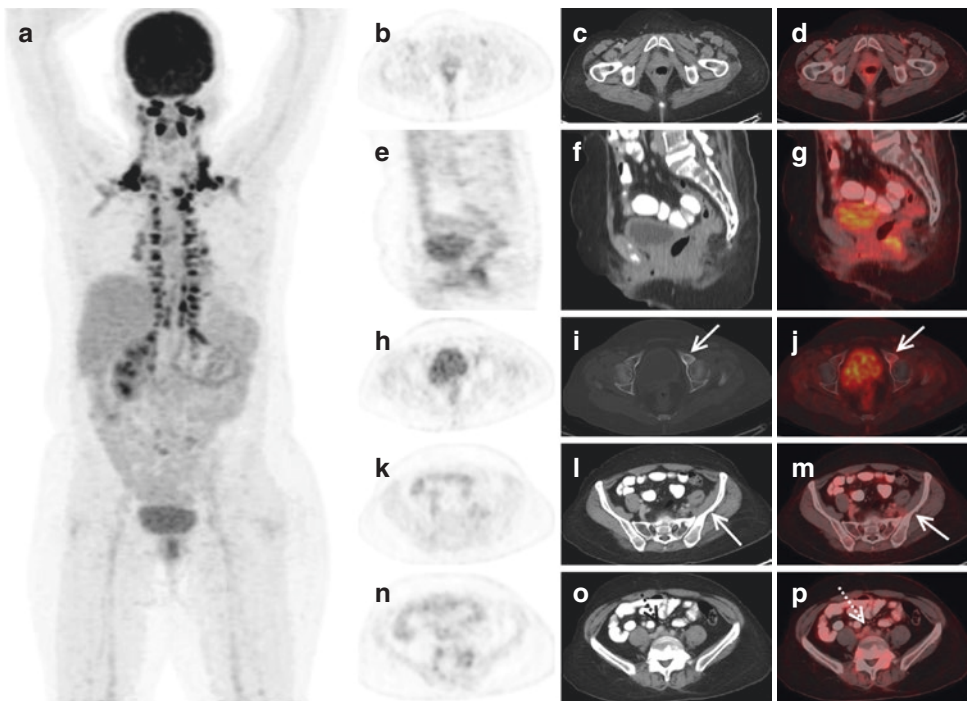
FDG PET/CT in a 43-year female with metastatic lesion in the L5 vertebra for unknown primary. The whole-body MIP images (a) showing abnormal areas of FDG uptake in the lower abdomen and pelvic regions. Abnormal FDG uptake was noted in the thickening in the upper vagina including vault as shown in the axial (b–d) and corresponding sagittal (e–g) PET, CECT, and fused PET/CT, respectively. FDG-avid lytic skeletal lesions were noted in the anterior lip of left acetabulum (dotted arrows; h and i), lytic destructive lesion in the left iliac
